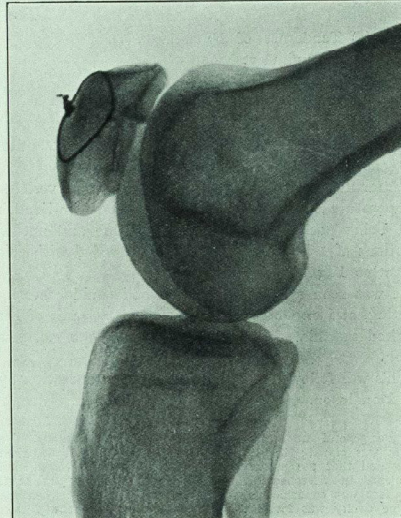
Case 19, Mrs. F. R.—, at. 33 years. X-ray photograph taken February, 1935. The "V"-shaped gap shown in the previous picture has been filled by bone, but the fracture lines are still visible.
